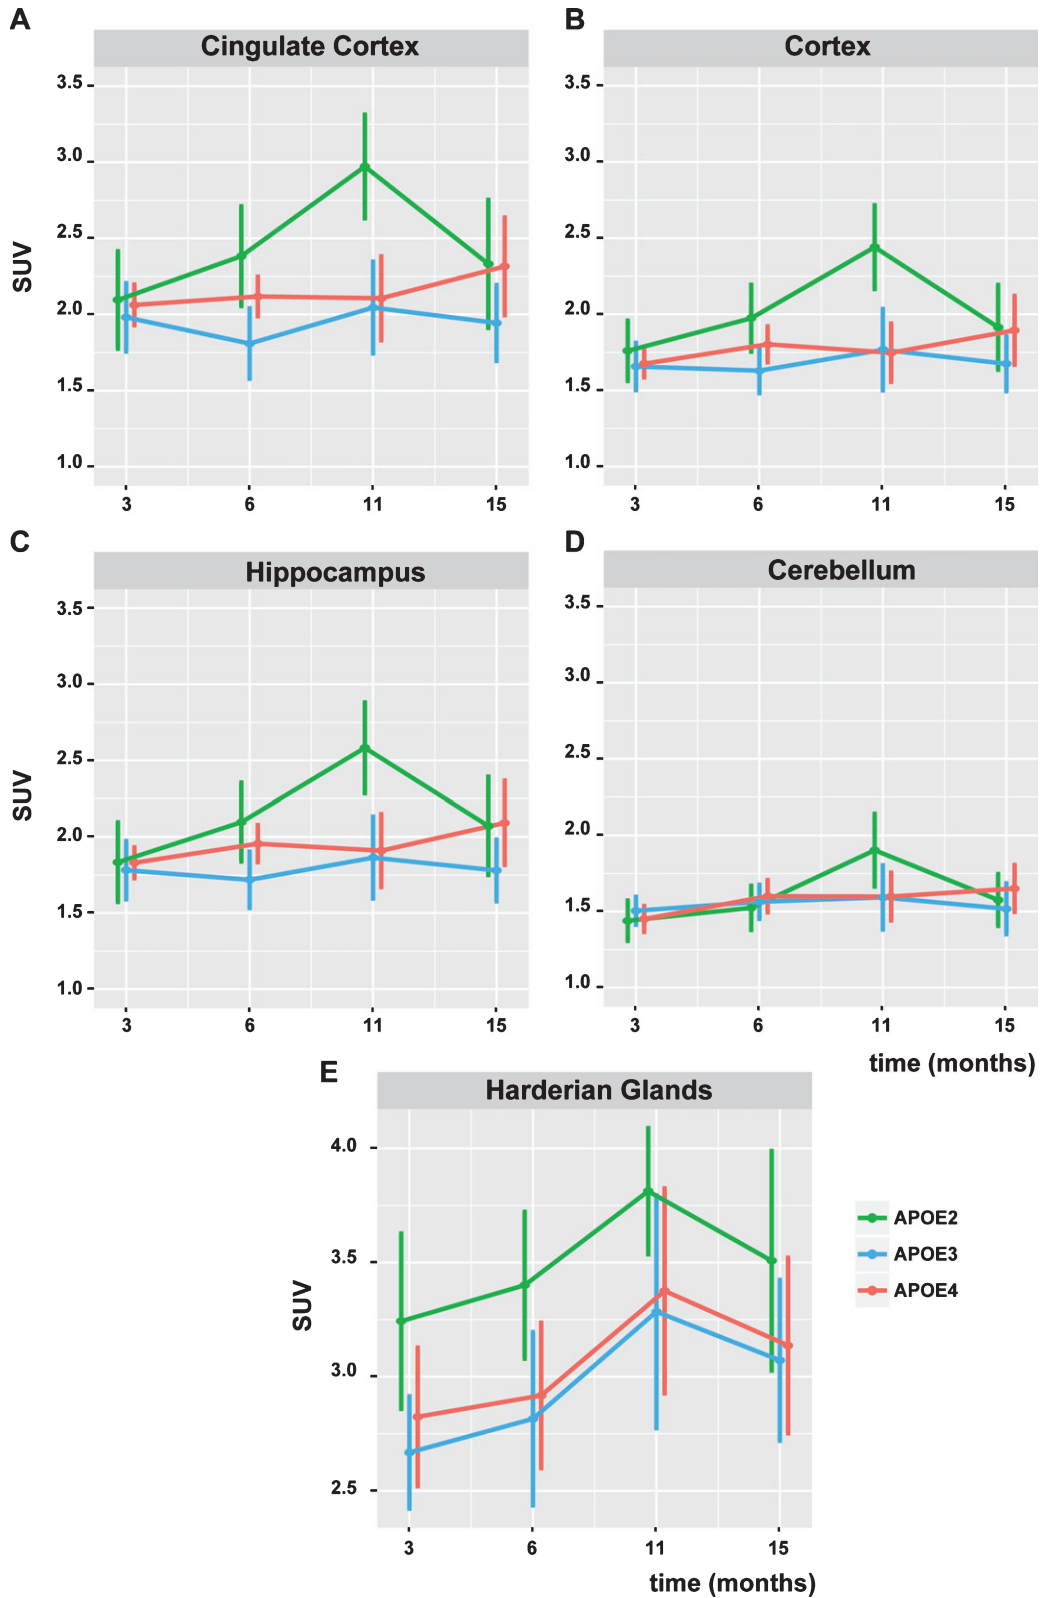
SUV uptake of [¹⁸F]FDG in cingulate cortex (A), cortex (B), hippocampus (C), cerebellum (D), and Harderian glands (D) at 3, 6, 11, and 15 months. Means and 95% confidence intervals are shown.
